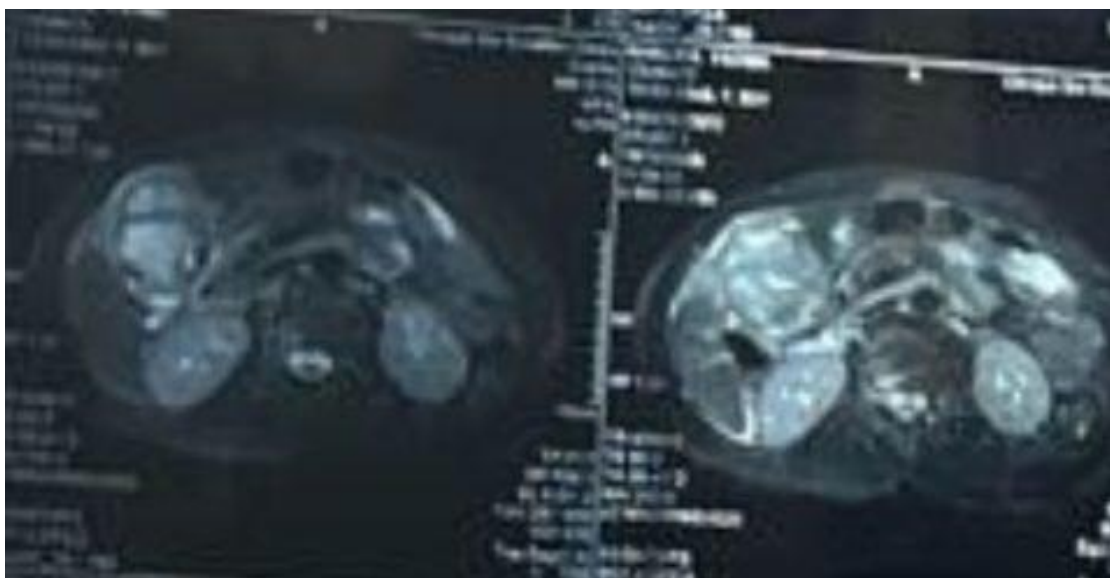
T2W axial MRI scan (A, B). A dilated, multiseptated gallbladder with irregularly thickened wall
